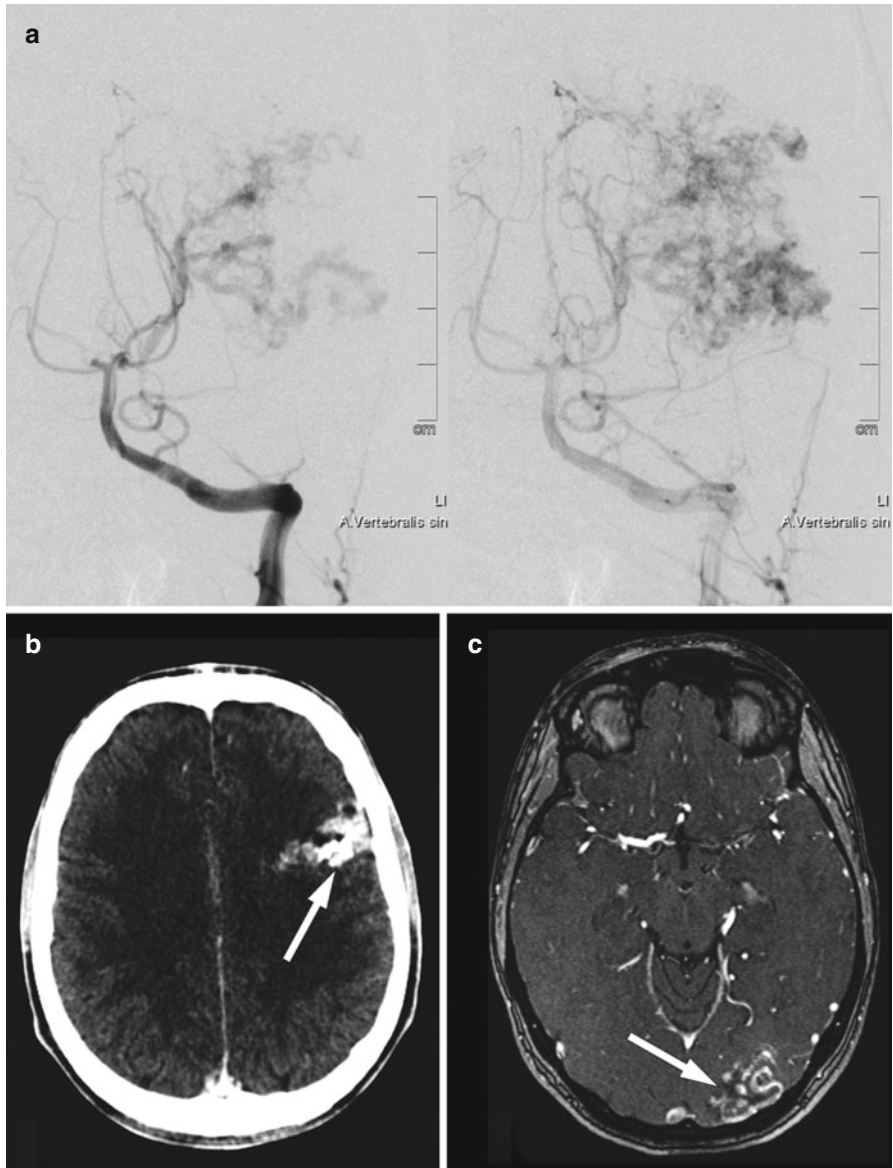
CTA and MRA for different patients with AVM. (a) DSA of the vertebral artery imaged in an earlier phase (*left*) giving more weight to the feeding arteries and imaged in a later phase (*right*) giving a better contrast to the nidus. (b) CTA and (c) MRA of a unilateral AVM of two different patients marked with a *white arrow*
